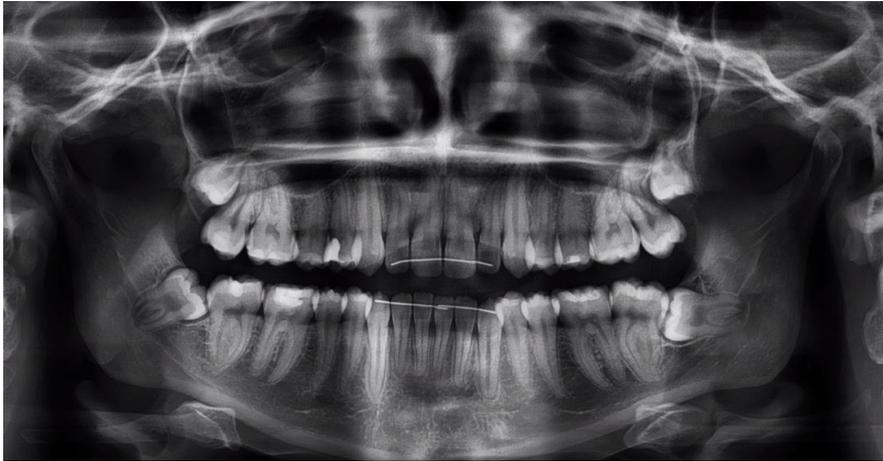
Panoramic radiograph of a patient with 32 permanent teeth. The four third molars are impacted.
